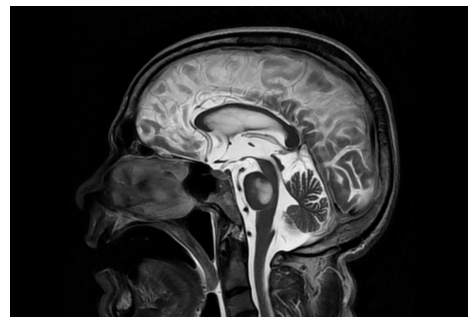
Case report 1 (FLAIR image shows hyperintense lesion in central pons).
